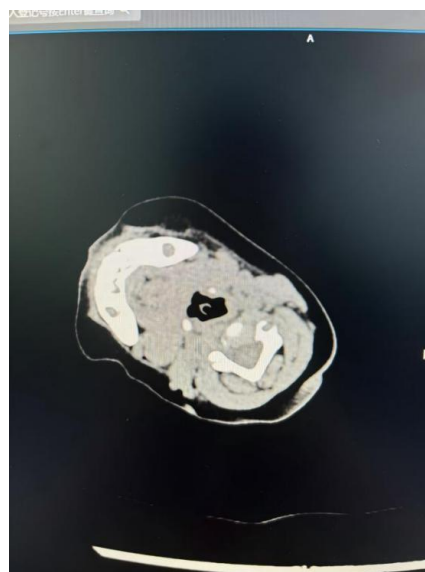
CT shows underdevelopment of the laryngeal cartilage.
